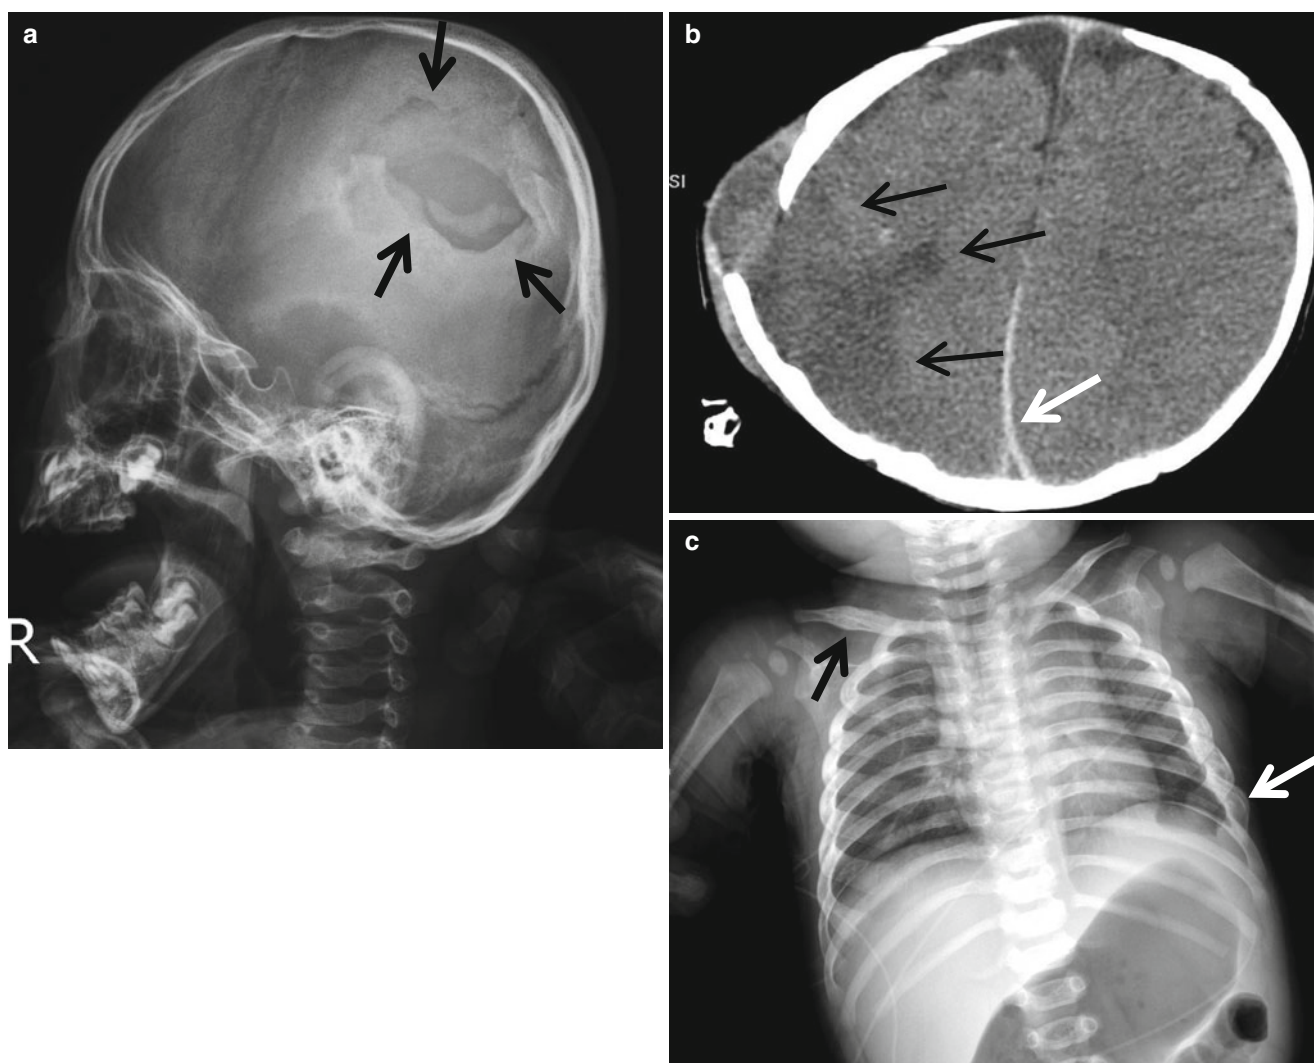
Leptomeningeal cyst in nonaccidental injury. (a) Plain radiogram shows a well-defined lucent area (*arrows*) at the prior fracture site. (b) CT scan shows herniation of the CSF space through the dural defect causing increased defect. Previously noted encephalomalacia is filled
